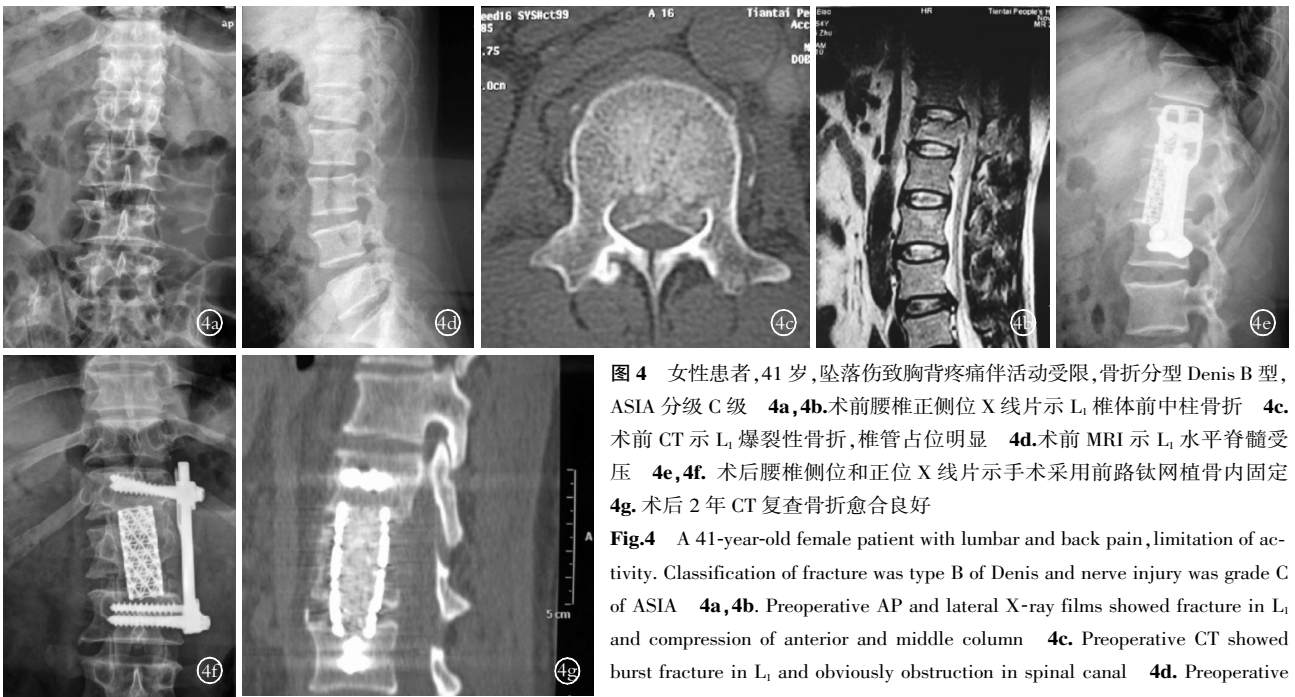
女性患者,41岁,坠落伤致胸背疼痛伴活动受限,骨折分型 Denis B 型, ASIA 分级 C 级 4a,4b.术前腰椎正侧位 X 线片示 L₁ 椎体前中柱骨折 4c.术前 CT 示 L₁ 爆裂性骨折,椎管占位明显 4d.术前 MRI 示 L₁ 水平脊髓受压 4e,4f.术后腰椎侧位和正位 X 线片示手术采用前路钛网植骨内固定 4g.术后 2 年 CT 复查骨折愈合良好
